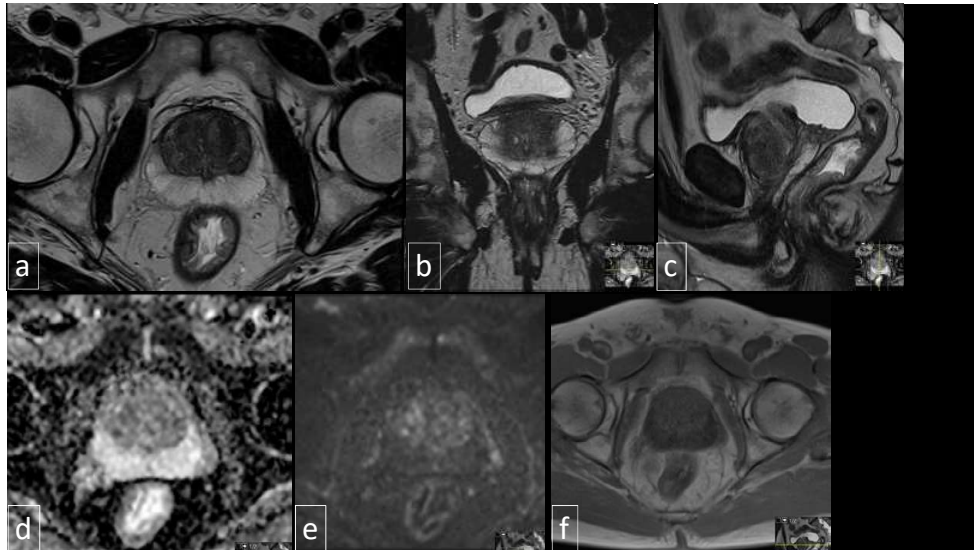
Normal prostate MRI at 1.5 T scanner at our institution. Upper row: T2W transversal (a), coronal (b) and sagittal (c) images. Lower row: Apparent Diffusion Coefficient (ADC) map (d), b 1500 calculated (e) and T1W (f). Collage Dr Thimansson.
